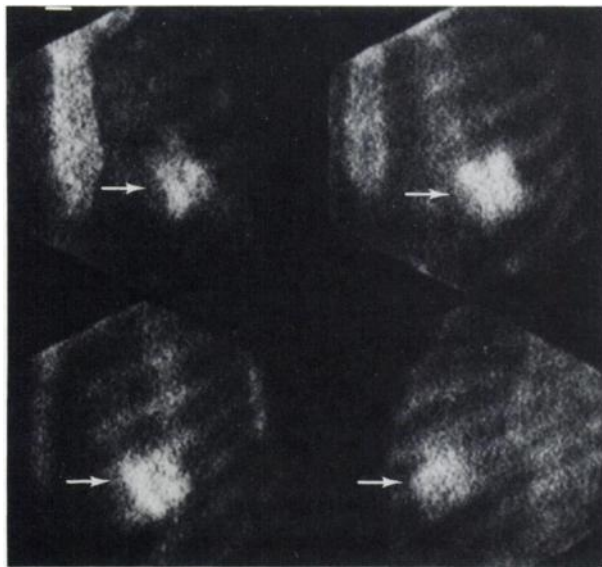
Technetium-99m-pyrophosphate scintigraphy of Patient 2 performed on the day after admission revealed multiple areas of intense uptake (→). The uptake is irregular and does not conform to the coronary artery territory. This is an unusual appearance for myocardial infarction due to coronary artery occlusion. Upper panel: anterior and LAO 30. Lower panel: LAO 60 and left lateral.
